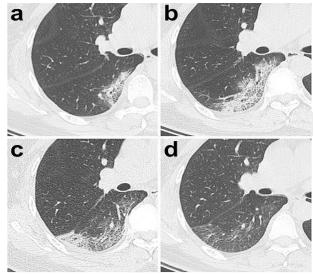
Typical evolution of CT findings in COVID-19 patient⁷
